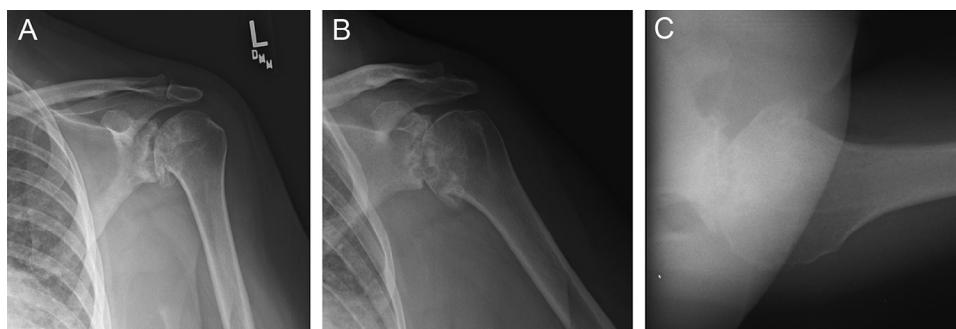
Preoperative (A) anteroposterior view (B) true anteroposterior view, and (C) axillary view radiographs demonstrate primary glenohumeral osteoarthritis with a biconcave (B2) glenoid.
